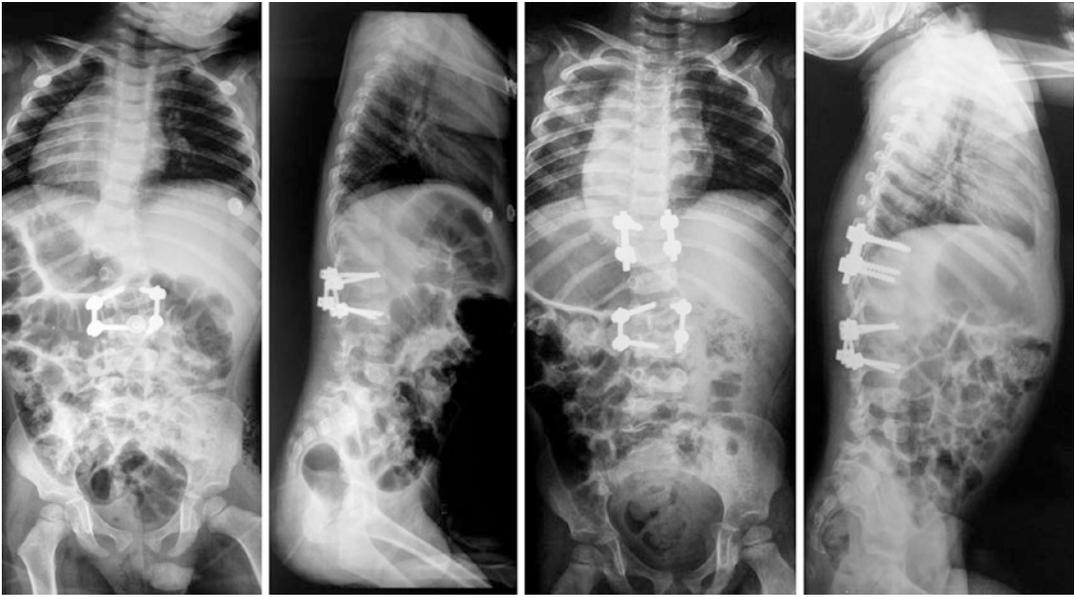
Postoperative P-A and Lateral X-ray examinations of both sessions. There was an apparent shoulder imbalance in the control X-ray of first session which was
